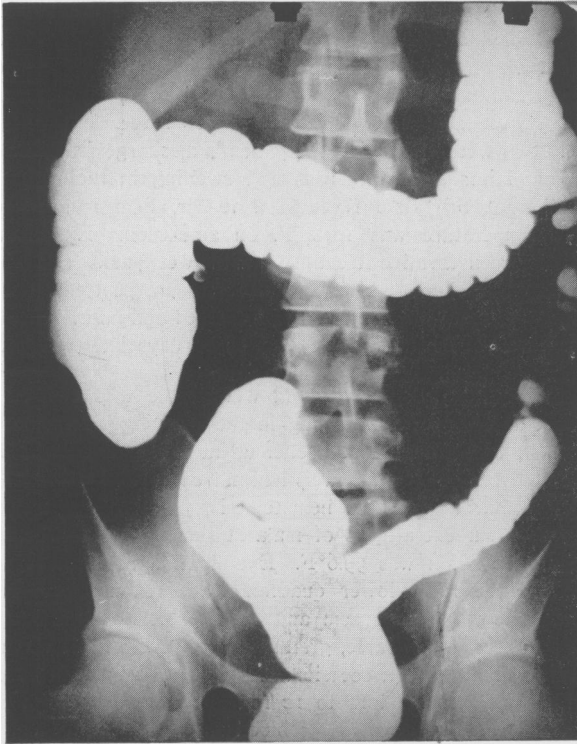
X-ray examination of colon with barium enema showing one additional small diverticulum on the medial aspect of the ascending colon near the hepatic flexure.
